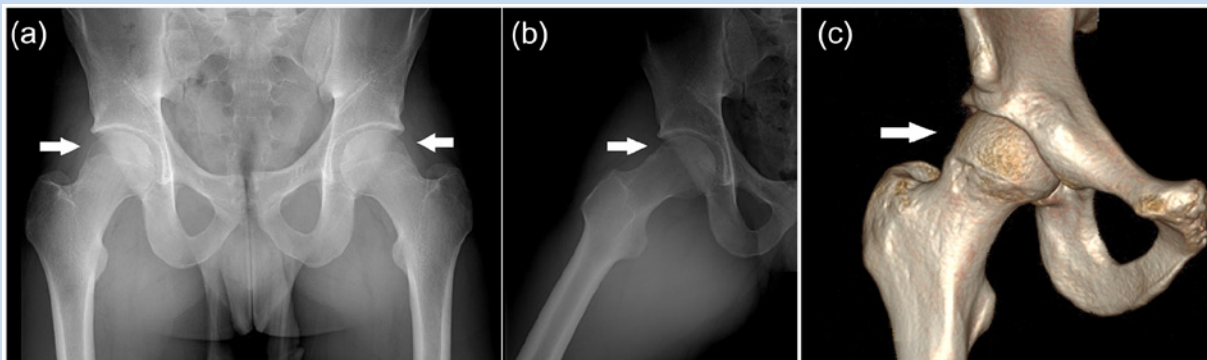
(a) AP pelvis radiograph demonstrating significant cam-type impingement lesions with loss of femoral offset in the bilateral hips. (b) Cam lesions are often located anterosuperiorly and are often better visualized on Dunn lateral views of the hip. (c) Three-dimensional CT scans of the cam lesion are used preoperatively to better define its margins.
